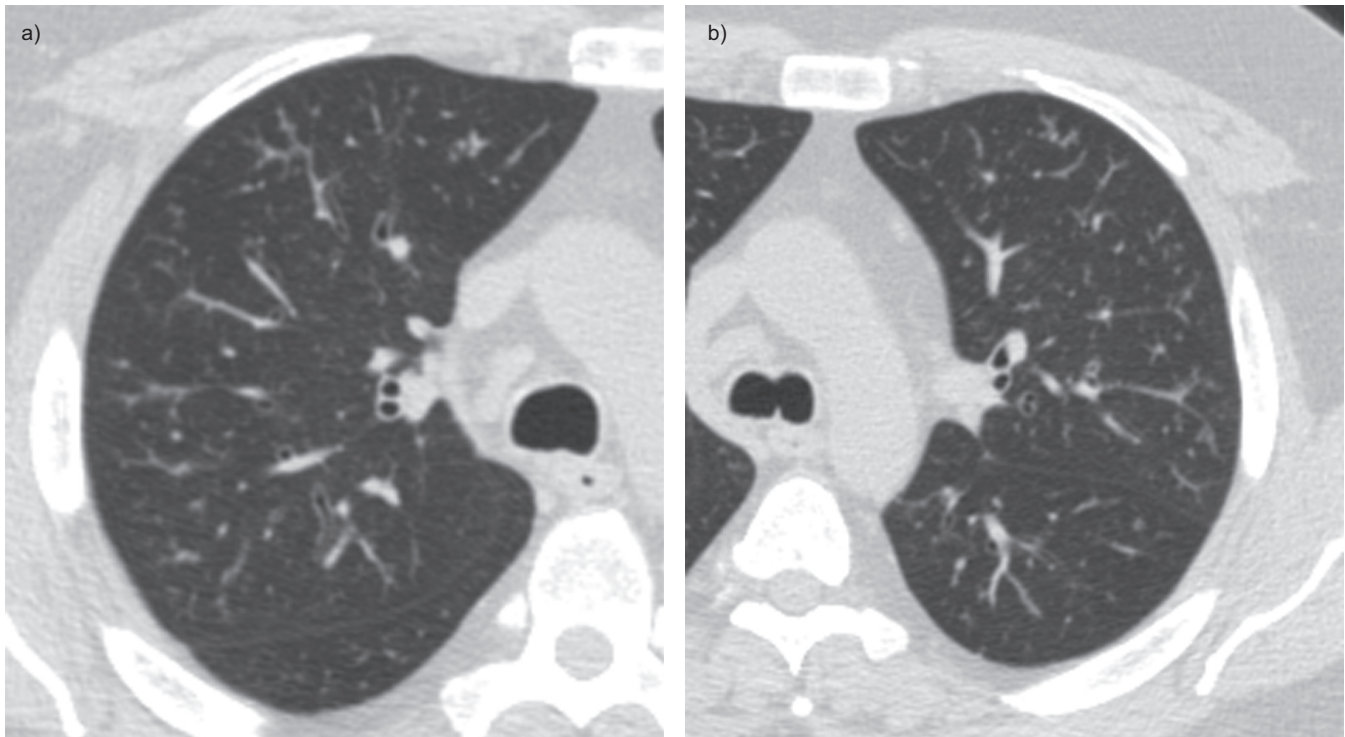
Volumetric computed tomography scans with high resolution of the chest in patient 1, demonstrating a tree-in-bud pattern and centrilobular nodules in the a) right and b) left lungs.
